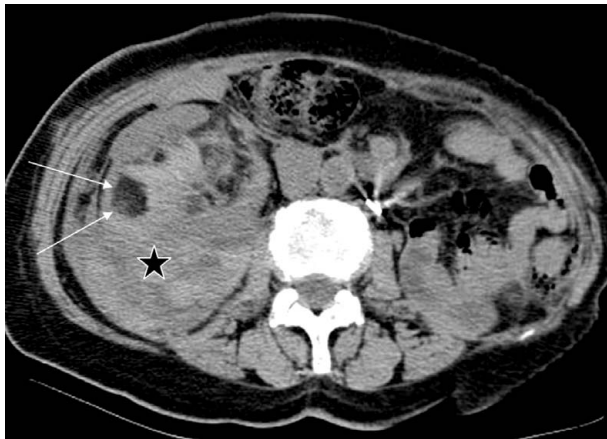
A 65-year-old male patient with acute right renal colic. Unenhanced computed tomography shows a fat-containing tumor in the right kidney with intra- and extrarenal hemorrhage (star). Note the area of fat density within the tumor (arrows), indicating its nature as an angiomyolipoma.
